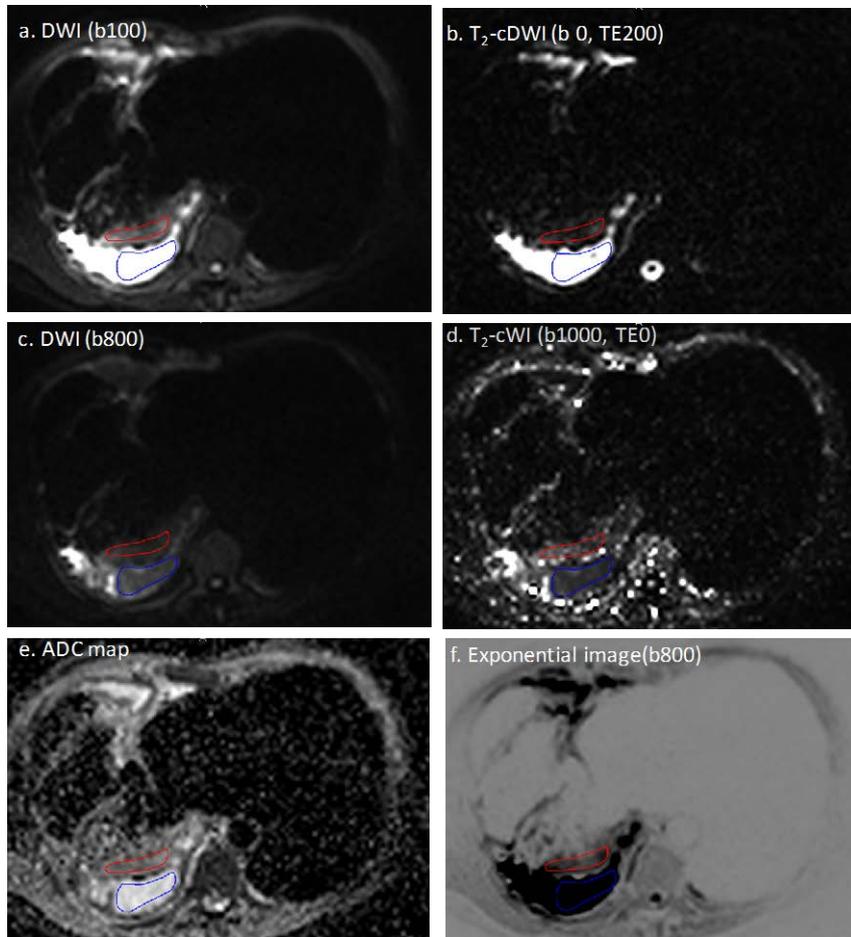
Axial DW MR images of a 69-year-old male with mesothelioma in the right lung for acquired b-values of (a) 100 and (c) 800 s/mm^2 at TE of 82ms, and (b) T₂-adjusted computed b-value of 0 s/mm^2 , echo time 200 ms, and (d) T₂-adjusted computed b-value of 1000 s/mm^2 , echo time of 0 ms. (e) ADC map ($\ast 10^{-3} \text{mm}^2/\text{s}$) was generated from images with b-values of 100, 500 and 800 s/mm^2 . (f) Exponential image with b 800 s/mm^2 .
